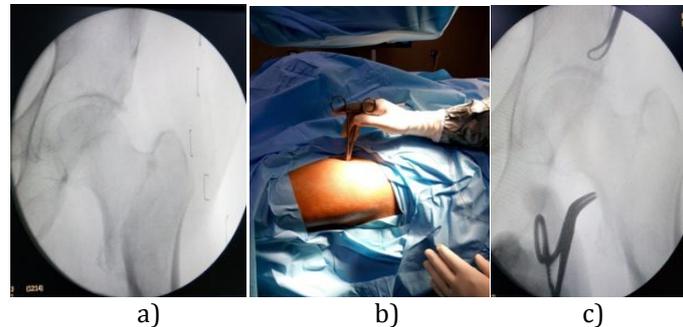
a) X-ray shows displaced trochanteric fracture and valgus deformity. b) Image shows the use of artery forceps from mini open anteriorly to push the proximal fragment to reduce the displacement. c) X-ray shows reduction of displacement.
